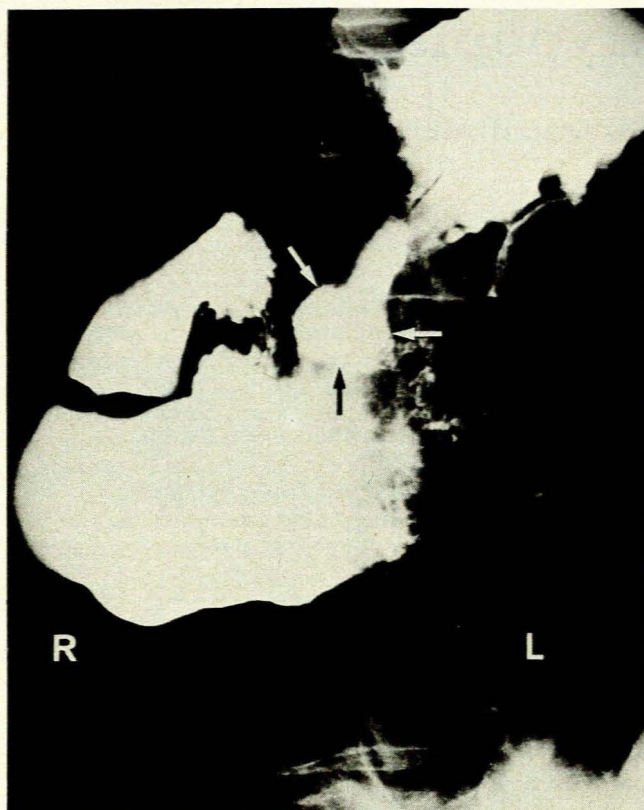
A selected view (slightly oblique supine) from a barium meal series taken 1 day after the radiograph in Fig. 1. The gastric ulcer in Fig. 1 is now clearly demonstrated as a contrast-filled crater viewed end-on. The 3 arrows delineate the outer contours of the ulcer.
